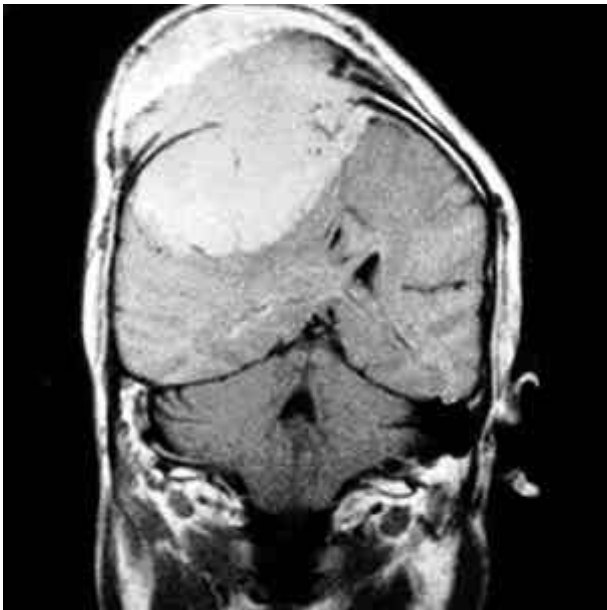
Preoperative Gd-DTPA enhanced T1W1 of MRI shows a huge homogeneously enhancing parasagittal convexity mass invading the cerebral parenchyma and scalp soft tissue. Destroyed cranial vault is noted.
